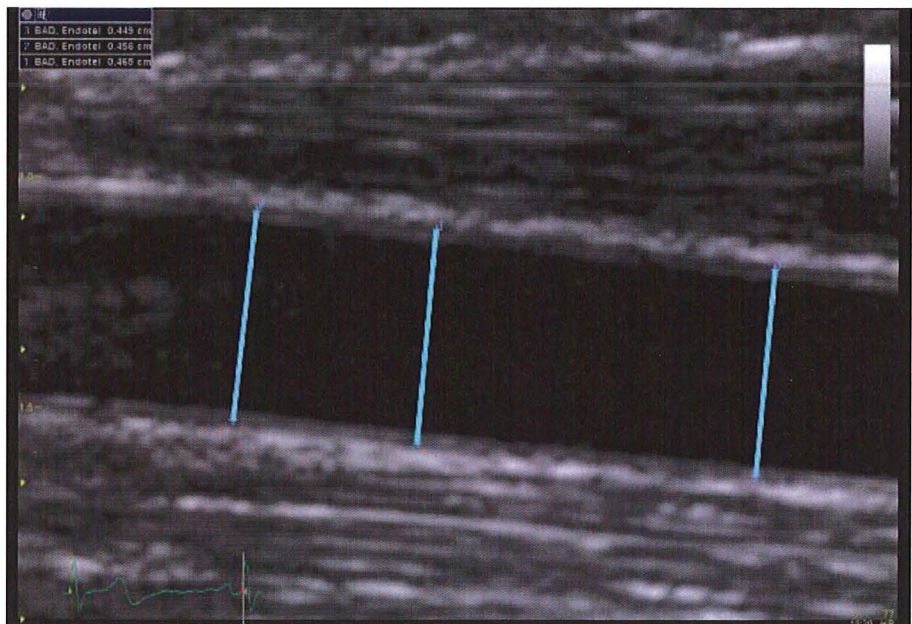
Example of an ultrasound image of a brachial artery in the dilatated state, with three measurements performed along the vessel with electronic callipers.
